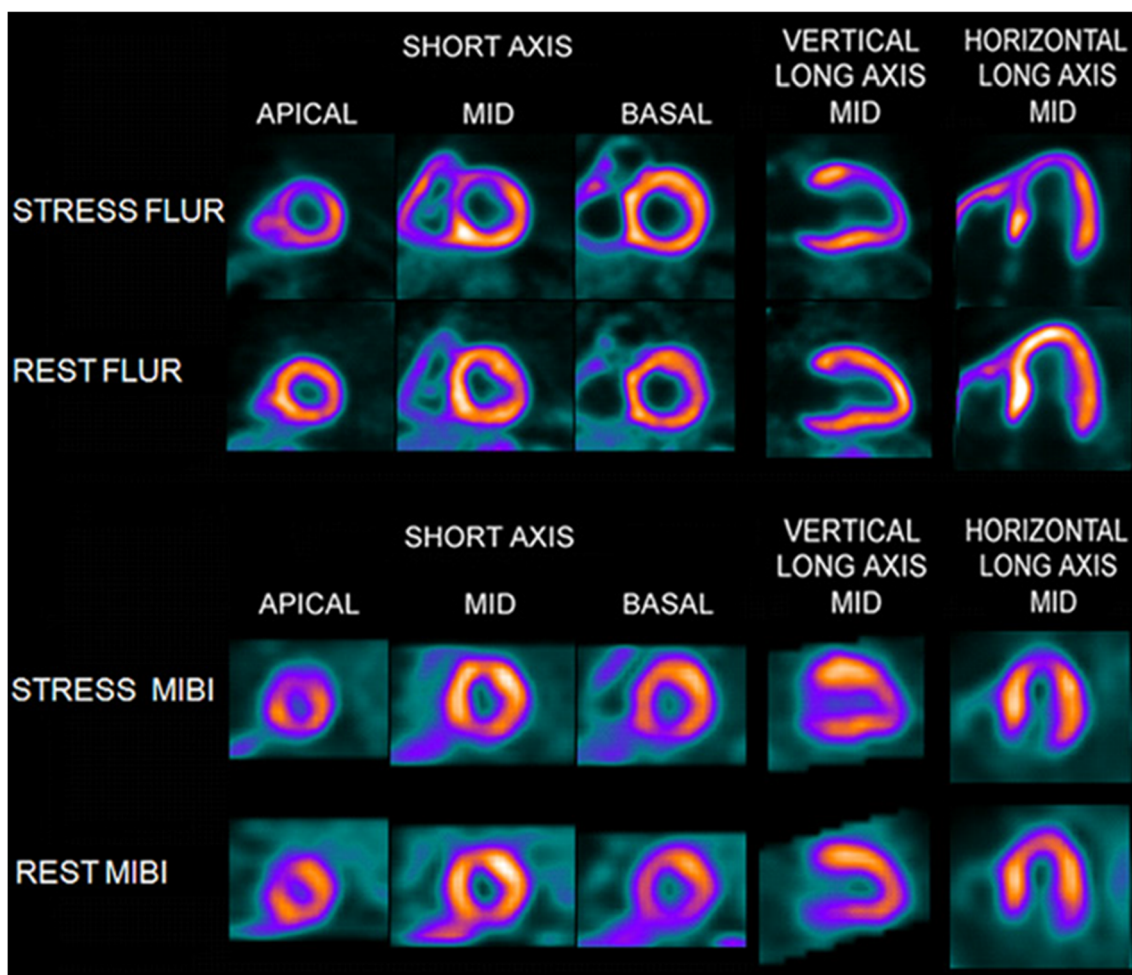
Myocardial perfusion images obtained with ^{18}F -Flurpiridaz (FLUR) PET (*top*) and $\text{Tc-}^{99\text{m}}$ sestamibi (MIBI) SPECT (*bottom*). The ^{18}F -Flurpiridaz images show a severe reversible perfusion defect throughout the territory of the occluded proximal left anterior
